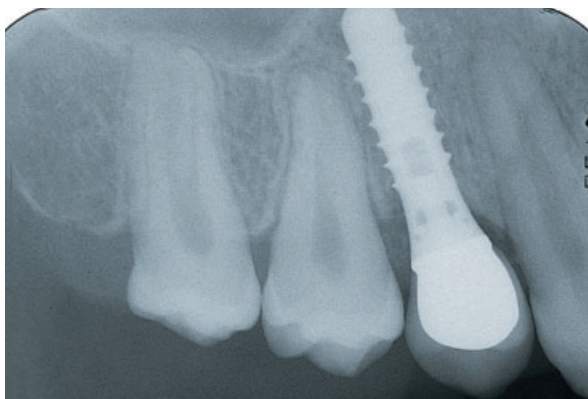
The follow-up radiograph taken 1 year after the insertion of the 12 mm solid screw implant, shows adequate marginal fidelity and stable conditions at the bone-to-implant interface.
